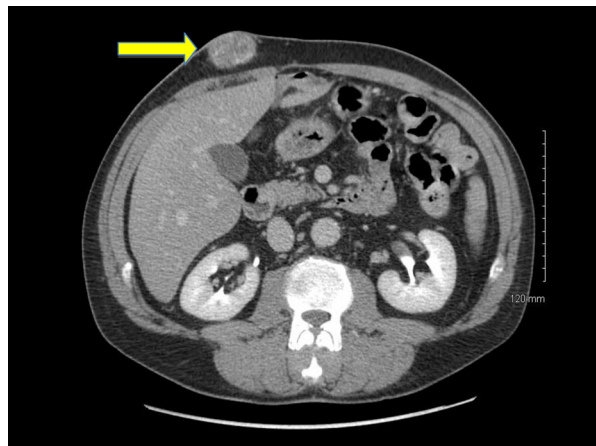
CT scan demonstrating a solitary, heterogeneous 6 × 4 cm mass of the right abdominal wall (arrow) with a distinct fat plane overlying the anterior rectus fascia. Diagnosis of sebaceous carcinoma was made upon surgical excision.
